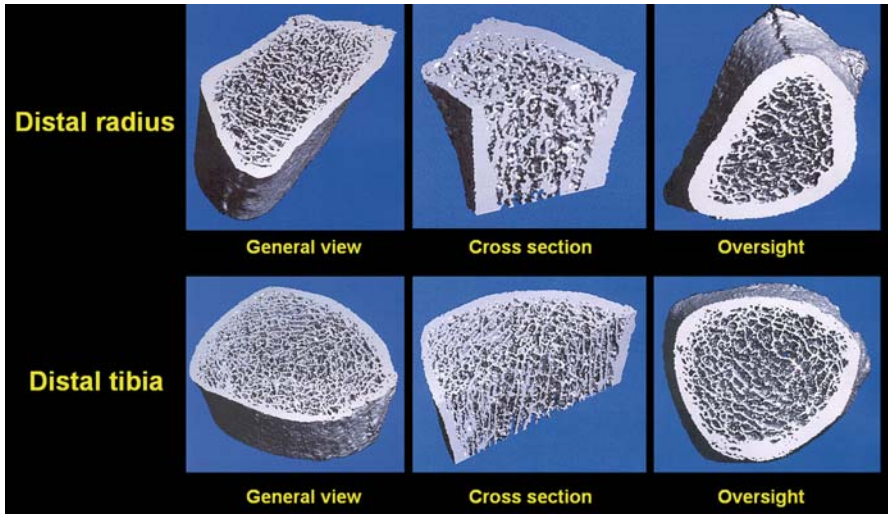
The Xtreme-CT: 3D structure presentations at various views of normal distal extremities
